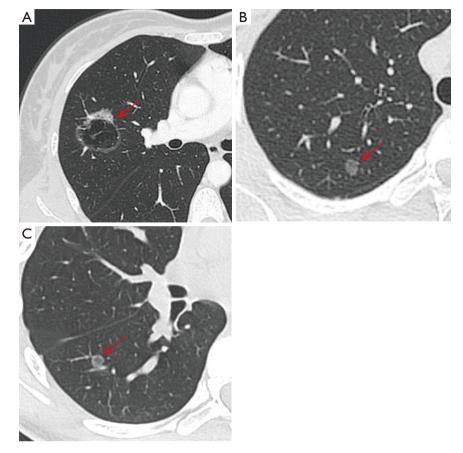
The computed tomography images for ground-glass opacity-featured lung adenocarcinoma. (A) The typical computed tomography image for a 38-year-old woman with lung cancer. (B,C) The typical computed tomography images for two 14-year-old teenagers with preinvasive lung cancer. Red arrows indicate lesions for patients with lung cancer.
